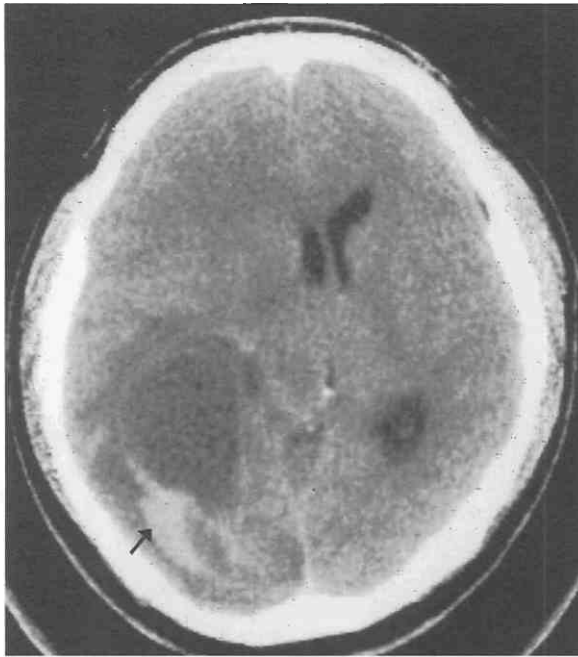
Intratumoral hemorrhage into large right posterior frontoparietal glioblastoma. Axial CT image without intravenous contrast. A large well demarcated hypodense cystic cavity in the deep right frontoparietal white matter is surrounded by poorly defined hypodensity. On the posterior margin of this cavity, there is a sharply defined scythelike hyperdense collection (*arrow*) representing intratumoral hemorrhage. Note the considerable mass effect secondary to diffuse edema in the right frontal lobe with shift of the lateral and third ventricles and the septum pellucidum to the left of the midline. The atrium of the left lateral ventricle is compressed and displaced anteromedially by this cavitated tumor.
